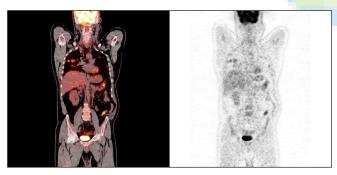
Pleura (SUVMax: 17) and lung metastasis (SUVMax:14) in PET/CT imaging was determined 52-years-old male patient's survival was calculated as 750 days.
